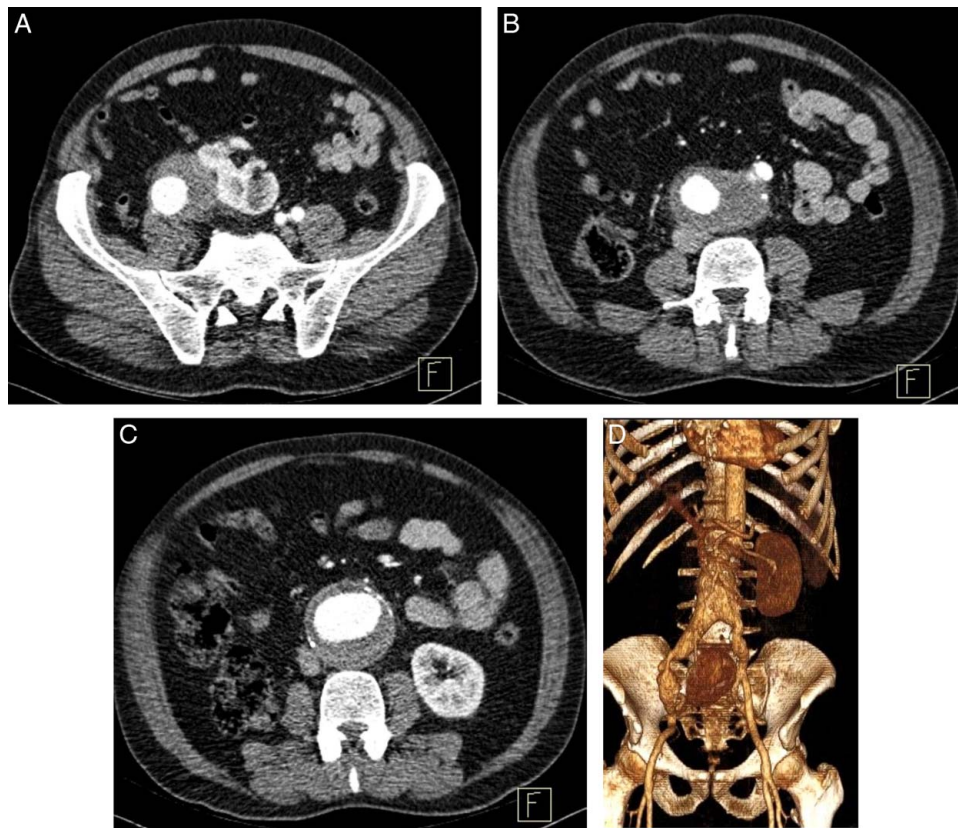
(A) Preoperative high-resolution Multi-Slice Computed Tomography Angiography (MS-CTA) image with an axial view. It shows the ectopic pelvic kidney and its anatomical position at the level of the abdominal aortic bifurcation. (B) Preoperative high-resolution MS-CTA image with an axial view. It shows the abdominal aortic aneurysm at the level of iliac bifurcation. (C) Preoperative high-resolution MS-CTA image with an axial view. It shows the largest diameter of the abdominal aortic aneurysm while demonstrating the normal anatomical location of the left kidney. (D) Preoperative high-resolution MS-CTA image with three-dimensional reconstruction in coronal view. It clearly shows the ectopic pelvic kidney with the subsequent arterial aneurysms.
